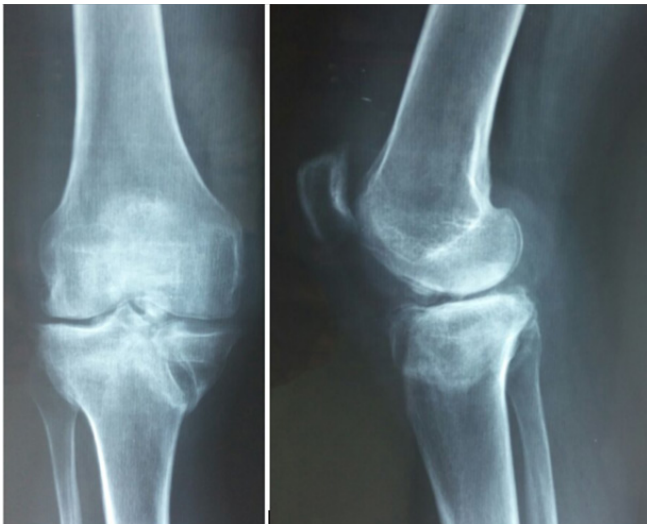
preoperative frontal and sagittal knee radiography
